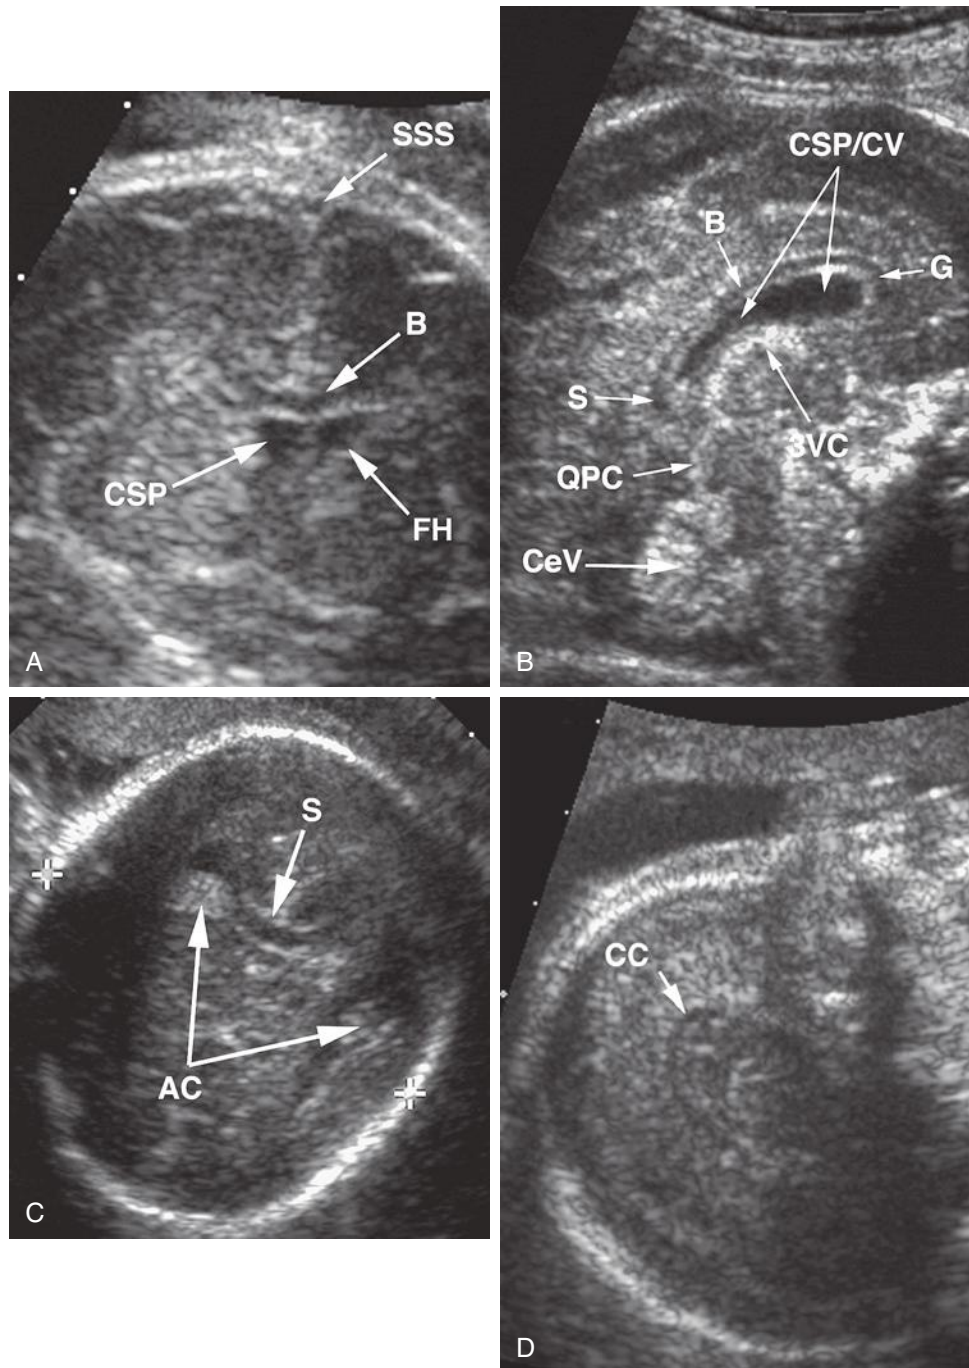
A, Coronal section through the body (B) of the corpus callosum. B, Midsagittal sonogram shows the corpus callosum to best advantage. C, Axial view “aimed” at the occiput demonstrates the splenium (S), the most crucial portion of the corpus callosum to visualize. In an “occiput up” fetus, a midsagittal sonogram of the corpus callosum would be nearly impossible to obtain. D, A 19-week fetus with corpus callosum well demonstrated. AC, atrial choroid; B, body; CC, corpus callosum; CeV, vermis of the cerebellum; CSP, cavum septi pellucidi; CV, cavum vergae; FH, frontal horn; G, genu; QPC, quadrigeminal plate cistern; S, splenium; SSS, superior sagittal sinus; 3VC, choroid plexus in the roof of the third ventricle.
